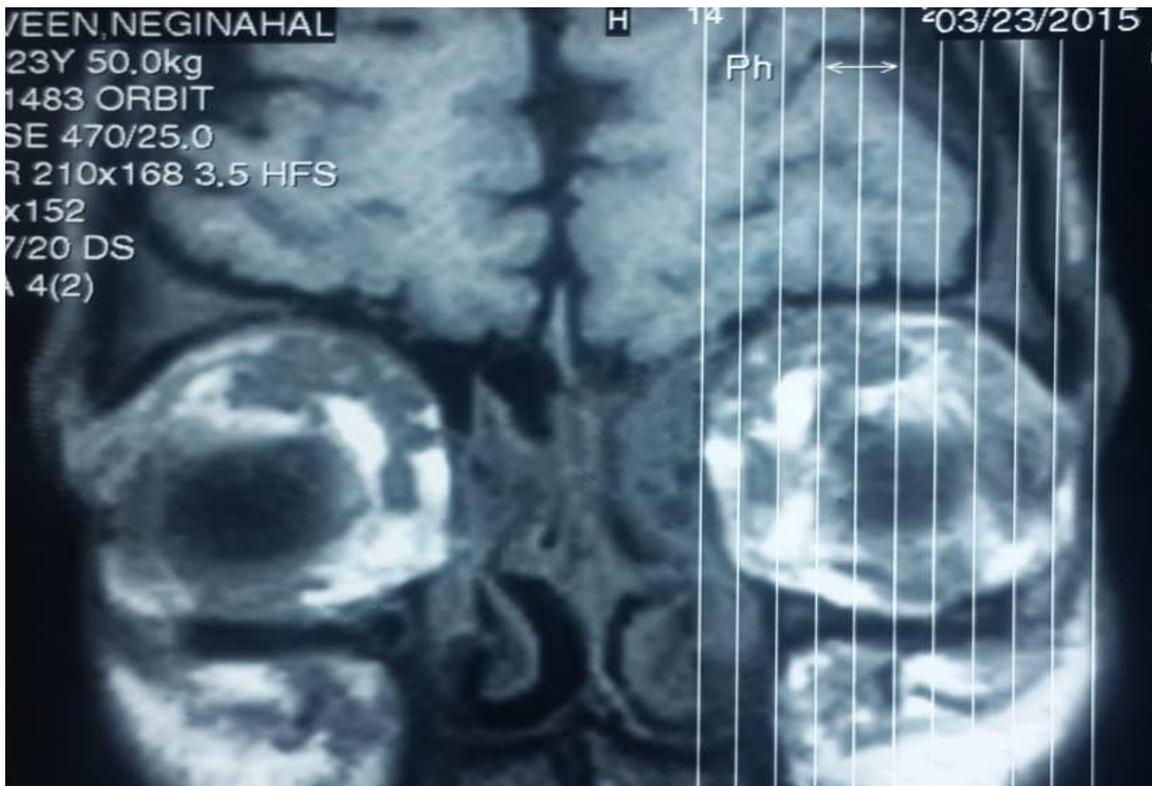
MRI plain showing Bilateral Orbital iso-intense lesions.
